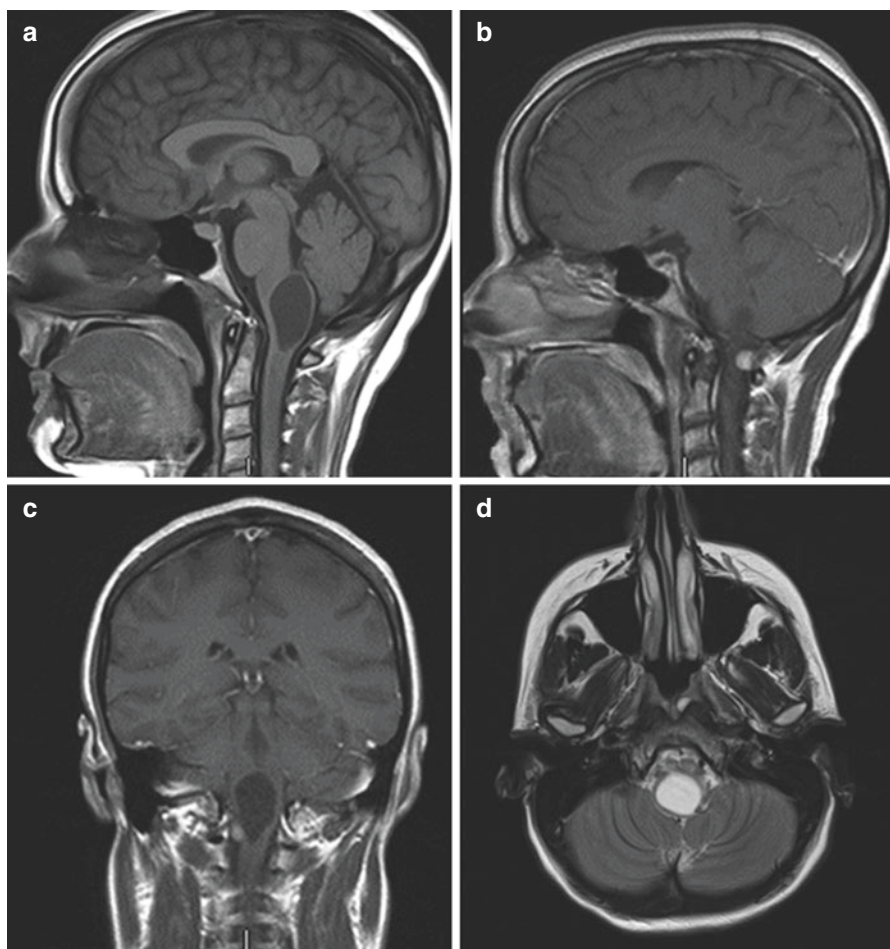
Medulla oblongata/brain stem hemangioblastoma (Patient 1: VHL disease, female patient operated by the senior author, KIA) [57]. (a) Preoperative MRI of brain. (b) Sagittal pre-contrast T1-weighted MRI showing medulla oblongata cyst. (c) Sagittal post-contrast T1-weighted MRI showing enhancing nodule. (d) Coronal post-contrast T1-weighted MRI showing enhancing nodule and adjacent cyst. (e) Axial T2-weighted MRI showing medullae oblongata cyst
